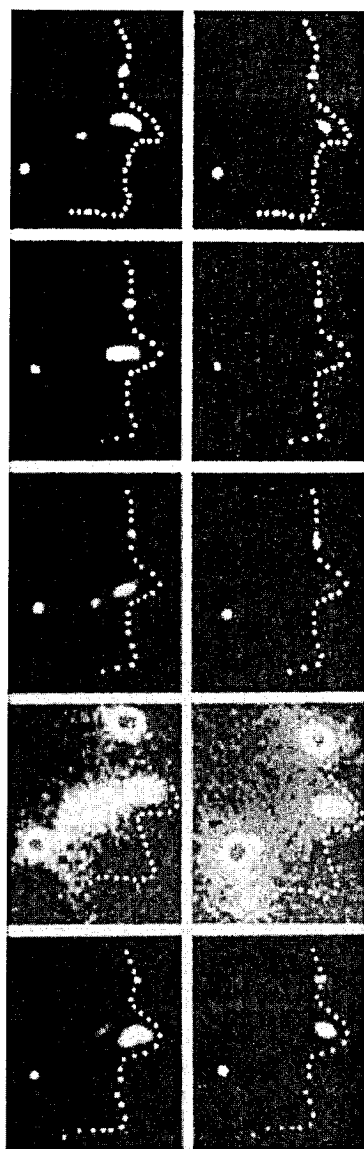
Gamma scintigraphy images of sites of deposition and patterns of clearance following administration of nasal formulations by nasal spray pump and rhinyle catheter containing various concentrations of methylcellulose. Each pair of images is from the same subject; however, the five pairs are from different subjects.
